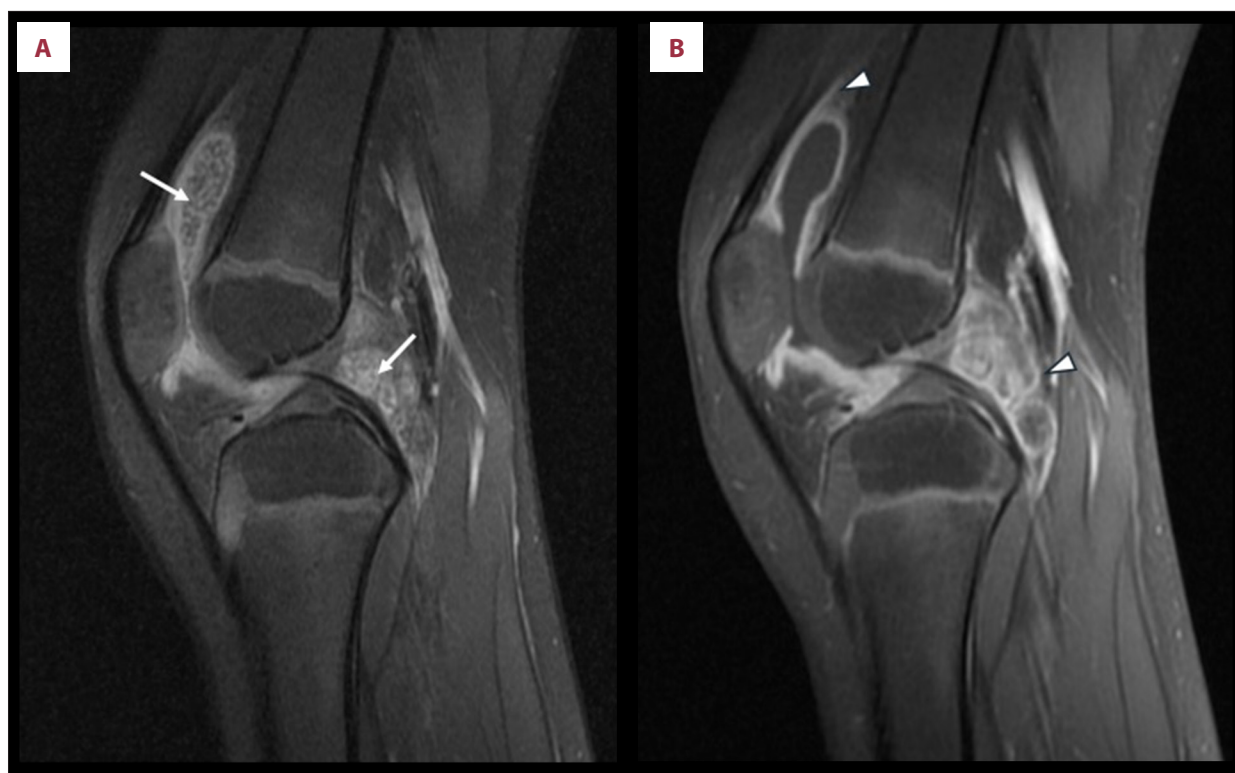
MRI scans with proton density fat suppression (A) and T1-weighted imaging with fat suppression after contrast (B) in the sagittal plane showing multiple foci of hyaline cartilage (arrow) associated with synovial thickening and contrast enhancement (arrowhead) in the suprapatellar recess and the posterior joint recess of the knee.
